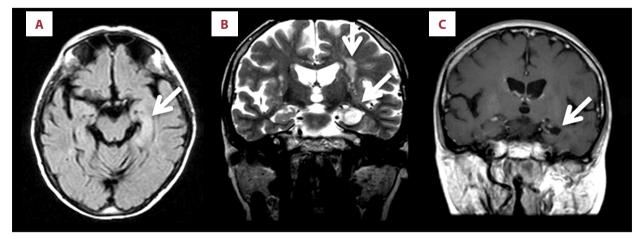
Axial FLAIR: (A) and coronal T2-weighted (B) images show increased abnormal signal intensity in the left hippocampalparahippocampal area (arrows) as well as multiple periventricular-deep white matter demyelinating lesions. Coronal postcontrast T1-weighted image (C) shows atrophy in the left medial temporal region (arrow) two weeks after the symptom onset.
